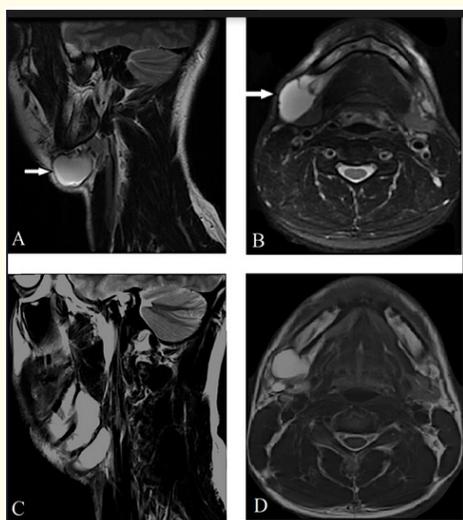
(A, B) Initial T2-weighted magnetic resonance imaging (MRI) shows a 2.2 x 3.9 x 3.1 (arrows) in the right submandibular space on sagittal and axial imaging, respectively. (C, D) Follow-up T2-weighted MRI obtained 3 months after bleomycin sclerotherapy depicts recurrence of the ranula.
